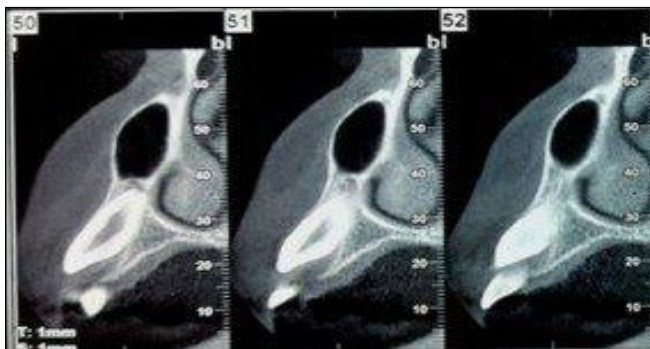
Detection of labio-palatal position of IMC using CBCT imaging of maxilla
